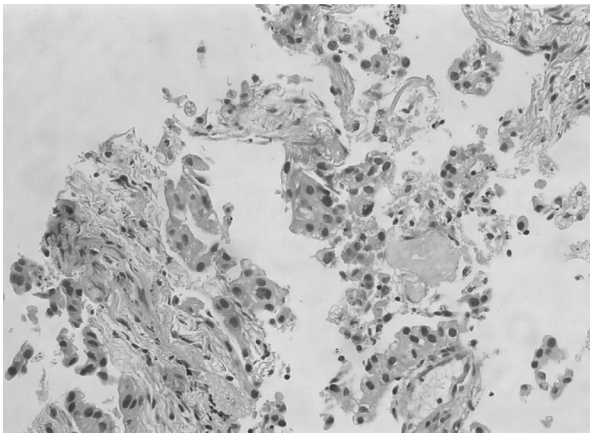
CT-guided lung biopsy shows the presence of atypical glandular structures with minimal stromal invasion in the limited stroma tissue. The stroma shows desmoplastic change with lymphocytic infiltrates and fibrosis. Focal reactive type II pneumocytes are also demonstrated. The pathologic diagnosis was adenocarcinoma.
